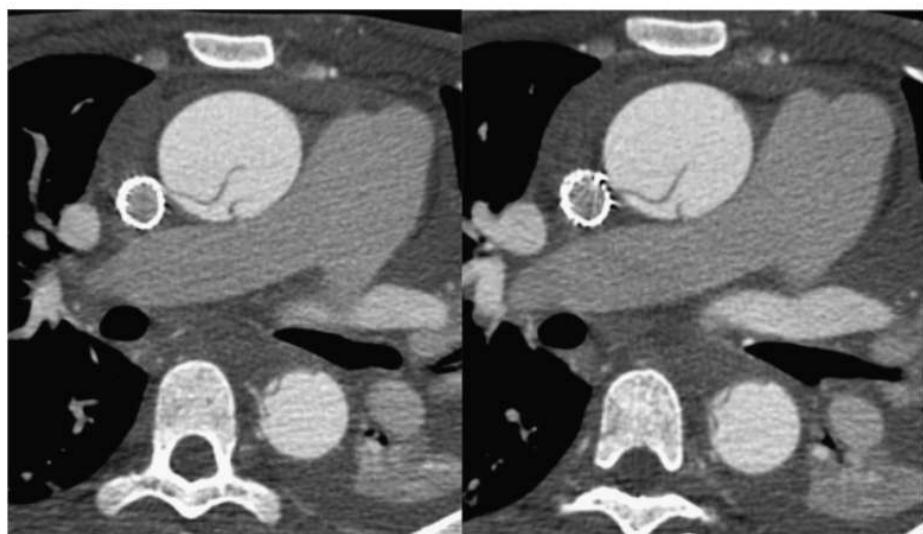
Axial computed tomography images of a patient with an acute aortic dissection.  A primary intimal tear in the ascending segment of the aorta.
